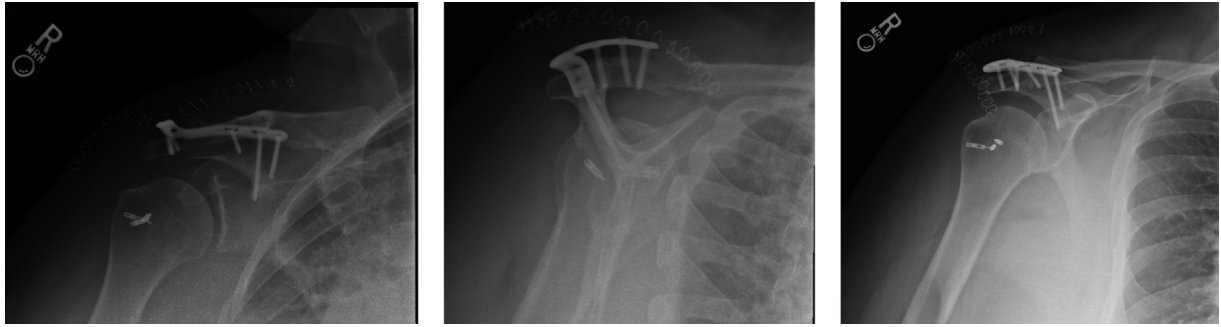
Intraoperative radiographs of plate fixation. Intraoperative images of acromion fracture plate fixation with a precontoured acromion plate.
